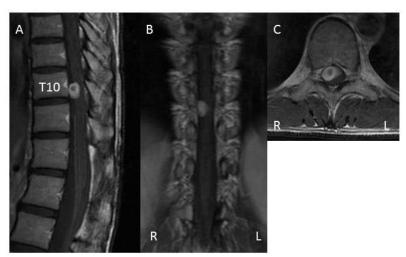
Preoperative magnetic resonance imaging of the thoracic spine showing an intradural extramedullary mass on the right anterolateral side at the T10 level (A) sagittal T1-weighted and contrast-enhanced image, (B) coronal T1-weighted and contrast-enhanced image, (C) axial T1-weighted and contrast-enhanced image
